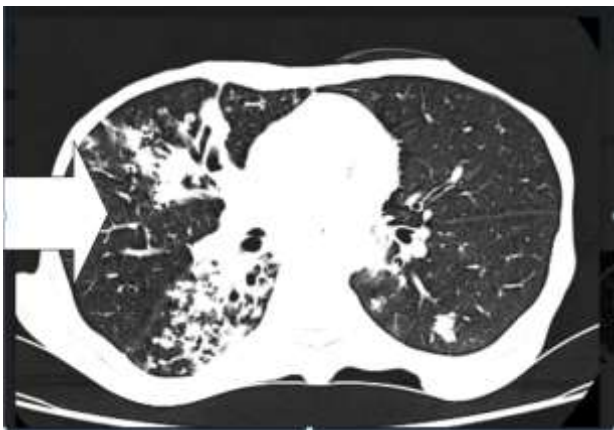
CT chest of tree budding appearance of the chest lesion.
